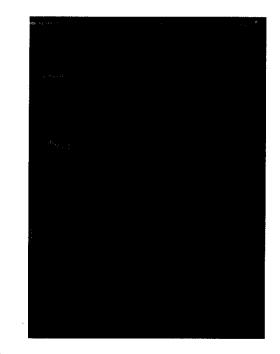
Laparoscopic intracorporeal ultrasonography revealing a common bile duct (*CBD*) stone (*straight arrow*). Note the echogenic object within the CBD casting a discrete acoustic shadow (*curved arrow*). PV = portal vein; IVC = inferior vena cava.
